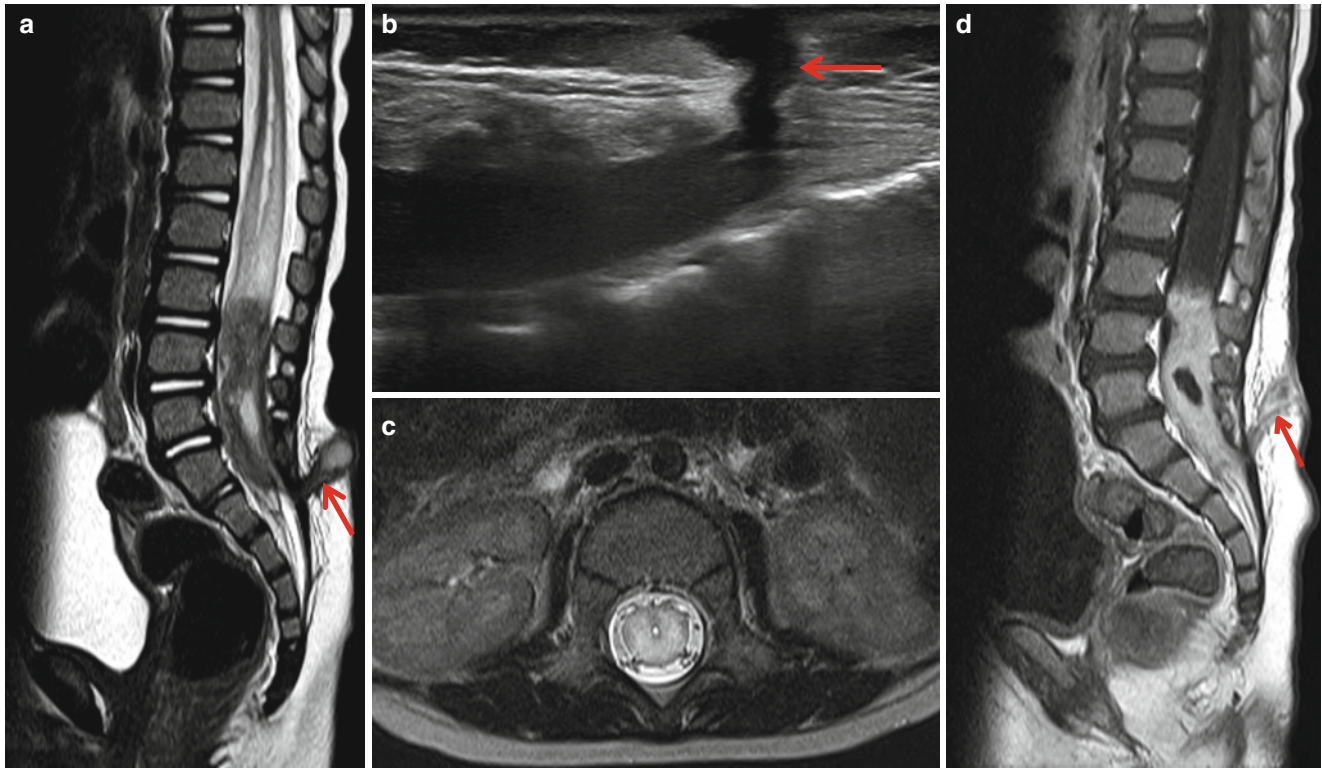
Dorsal dermal sinus with intraspinal infection. (a) Dermal sinus tract (*arrow*) is connected with edematous low-lying spinal cord. Distal spinal cord shows heterogenous low signal intensity. (b) Spinal US demonstrates dorsal dermal sinus tract (*arrow*) connected with distal spinal cord. (c) Axial T2-weighted image shows diffuse swelling
